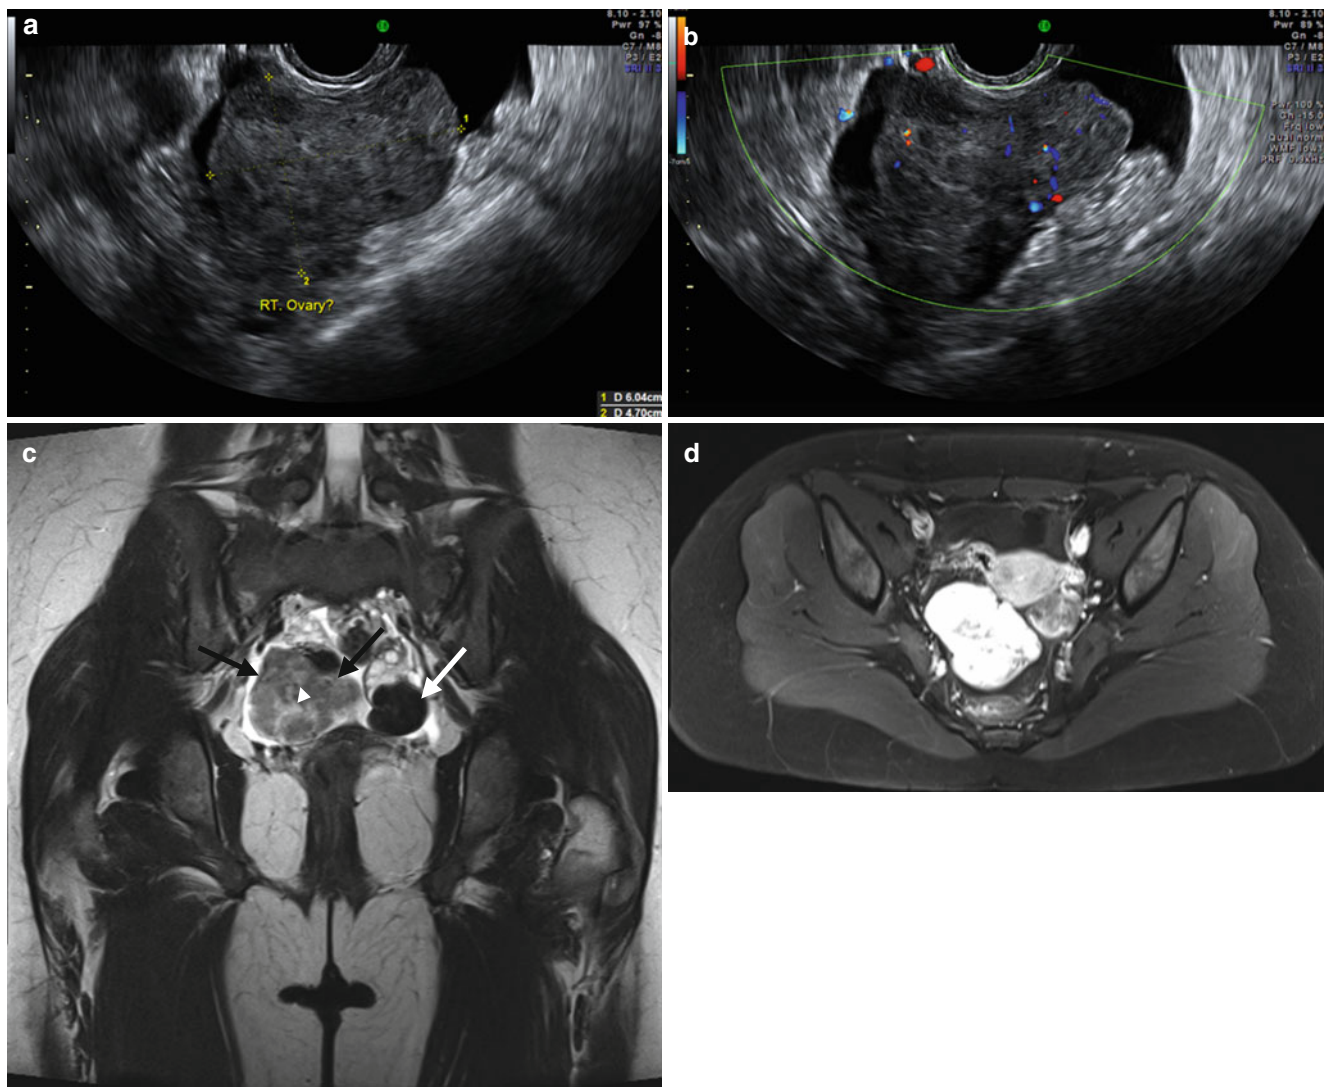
Bilateral ovarian fibromas appearing as a predominantly solid mass in a 14-year-old girl. (a, b) Endorectal US scans of pelvis show a solid mass without increased color flow in right adnexa. Coronal T2-weighted (c) MR image shows a heterogenous low-intense, solid mass (dark arrows) containing central, high-intensity, necrotic foci
